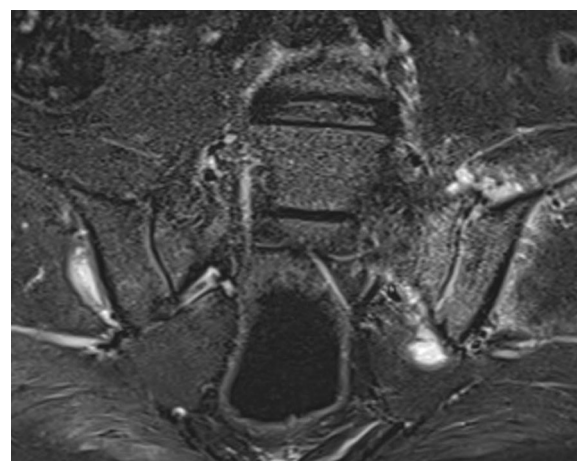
Magnetic resonance imaging in the coronal plane shows inflammatory bone edema and bone erosions or partial bone destruction at the articular surfaces of the sacroiliac joints
